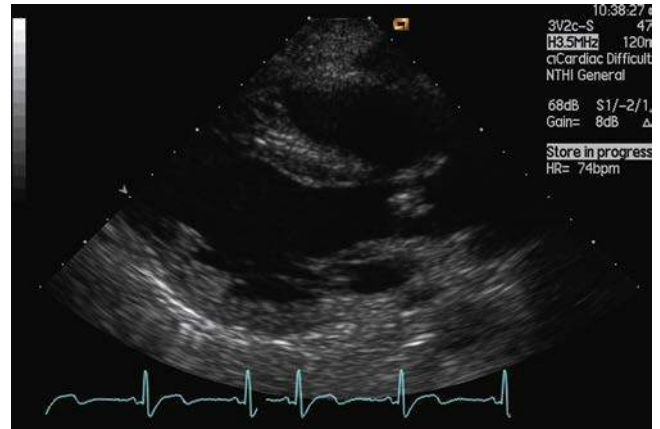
Parasternal long-axis transthoracic echocardiogram of a calcific aortic valve with an eccentric closure line and restricted cusp mobility.
